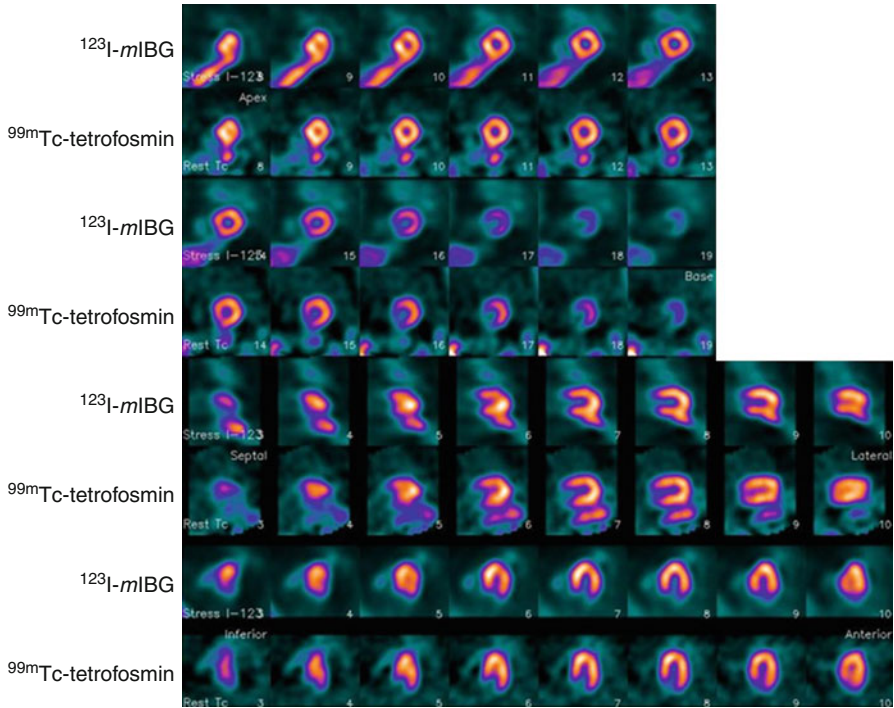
Aligned [^{123}I]-MIBG and $^{99\text{m}}\text{Tc}$ -tetrofosmin MPI SPECT images from an 82-year-old female with no history of heart disease show normal innervation and perfusion. *Top* four rows represent reoriented short-axis images, followed by vertical and horizontal long-axis views
